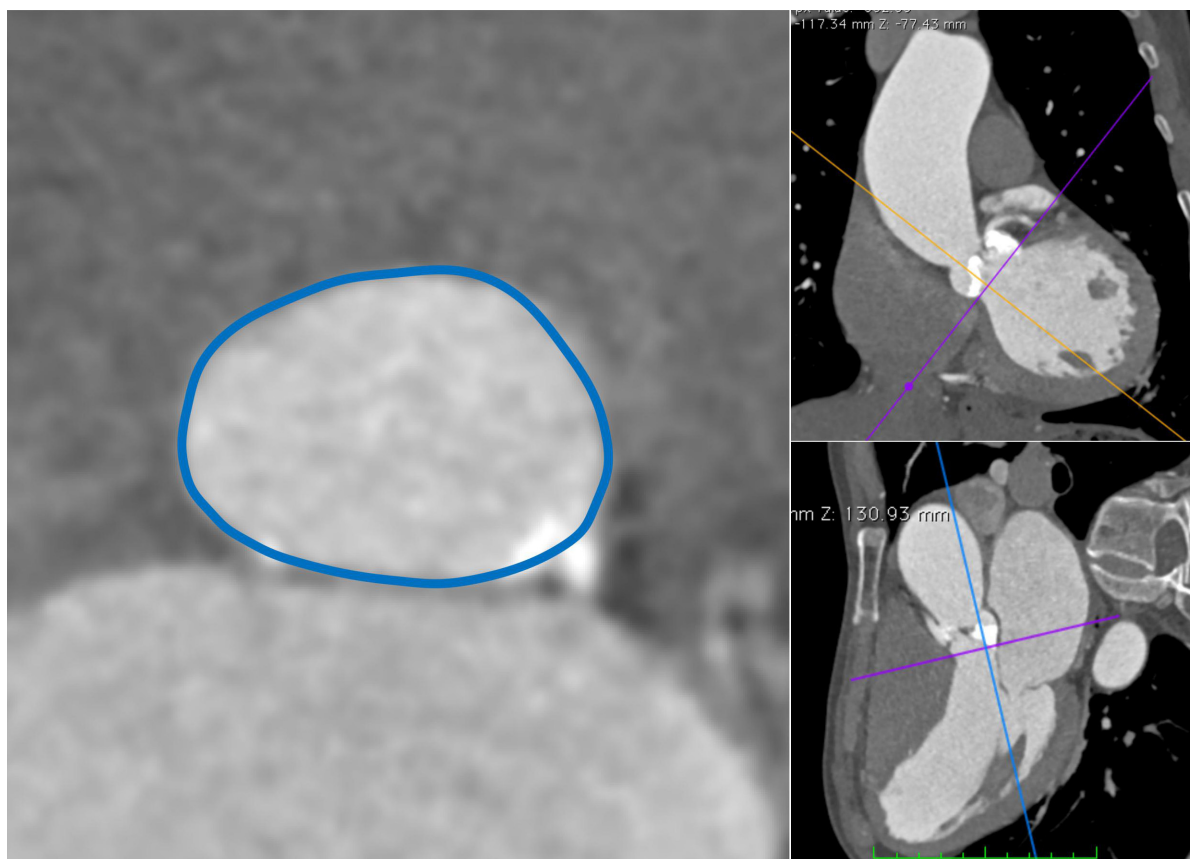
Annular structure assessment based on CT measurement (note the CT images in Figs. 2,3 are from the same patient). The annular area and perimeter were measured at the insertion point of the aortic cusps (blue contour), and the position of annular plane is shown in the CT image (purple line).
